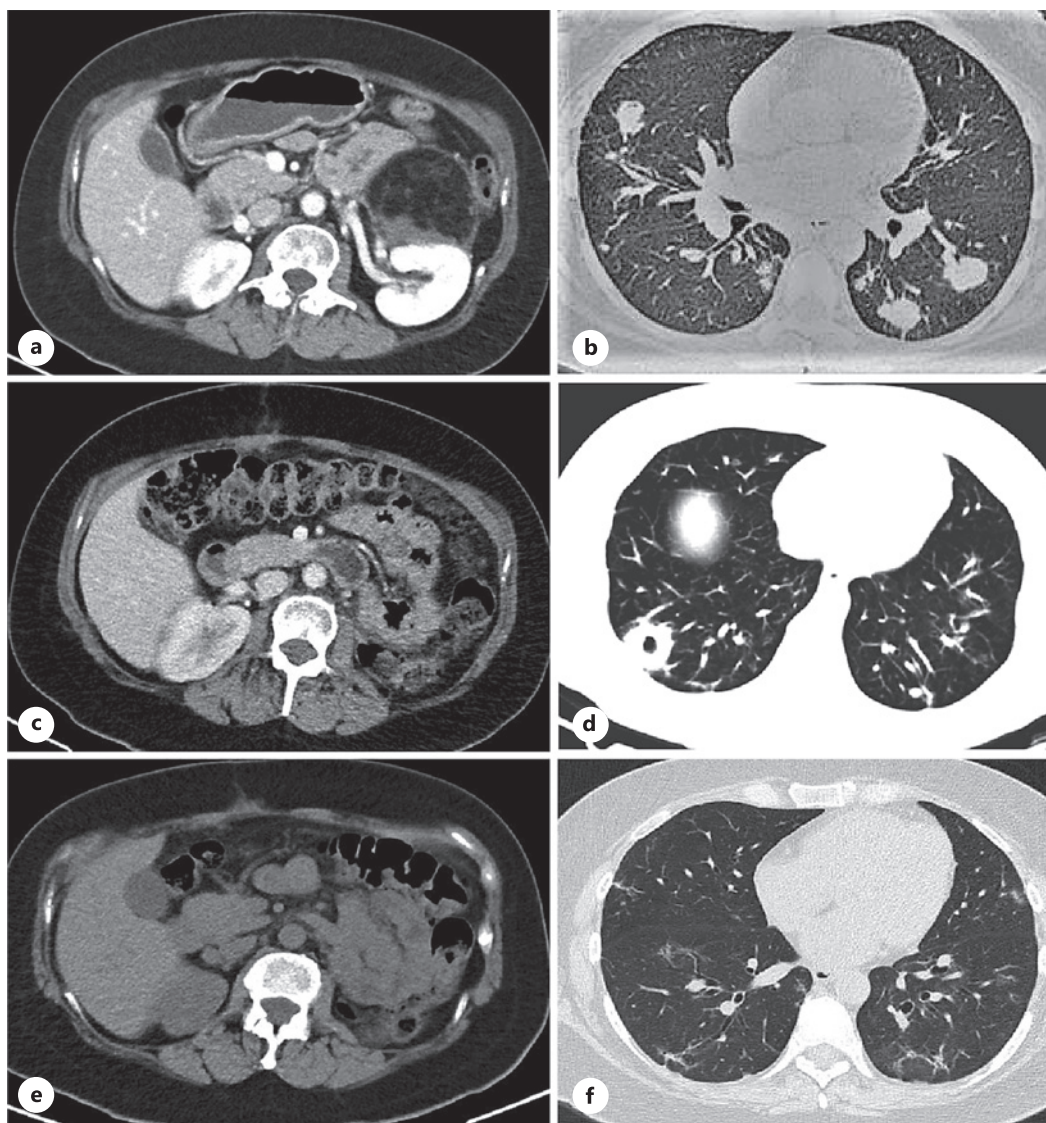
Computed tomography (CT) images at diagnosis (a, b) and post-surgery (c–f). a Abdominal CT scan at diagnosis showing a left intra-abdominal tumor measuring 22 × 12 × 14 cm, located intraperitoneally and retroperitoneally. It shows a fatty component with soft tissue density. b Chest CT scan at diagnosis showing multiple rounded nodules of varying sizes with well-defined edges in both lung fields, with the largest nodule measuring 35 mm density of 50 HU. c Post-surgical CT scan of the pelvis, taken 41 days after surgery, showing no evidence of neoformative lesions, lymphadenopathy in the iliac chains, or free fluid, with no significant changes compared to the previous study. d Post-surgical CT scan of the chest, taken 41 days after surgery, reveals an enlargement of pseudonodular lesions in both lungs and the emergence of a new cavitated nodule in the right lateral basal segment. e Post-surgical CT scan of the pelvis without contrast, taken 180 days after surgery, showing no evidence of neoformative lesions or lymphadenopathy in the iliac chains, with no significant changes compared to the previous study. f Post-surgical CT scan of the chest without contrast, taken 180 days after surgery, showing a stable disease with no progression of pseudo-nodules in both lungs compared to the previous study. No cavitated lesions are observed, and mediastinal lymphadenopathy appears to be reactive due to its stable evolution.
